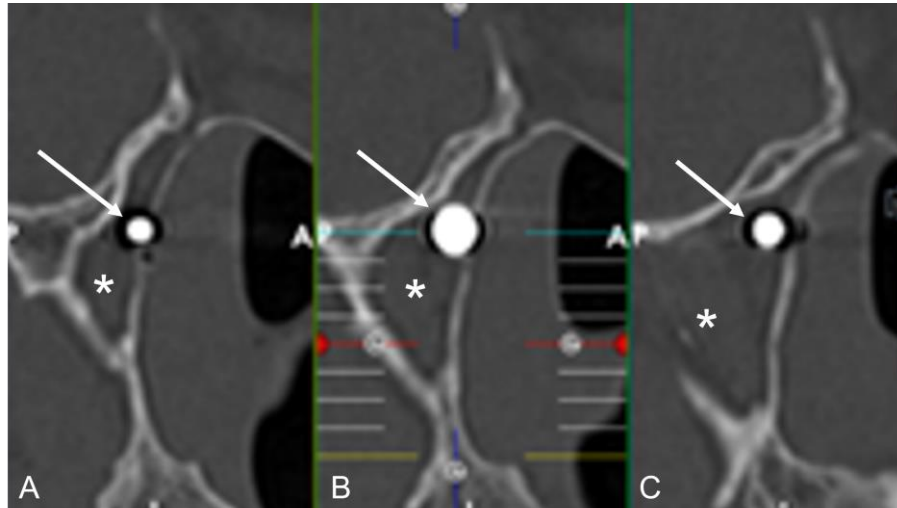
Position of the bullet in the *left pterygopalatine fossa on axial images of CT scan. A. Upper part of the bullet is trapped in the posterior wall of the left maxillary sinus. B. Major part of the bullet is situated close to the posterior wall of the left maxillary sinus. C. Inferior part of the bullet is situated deeper in the left pterygopalatine fossa.
